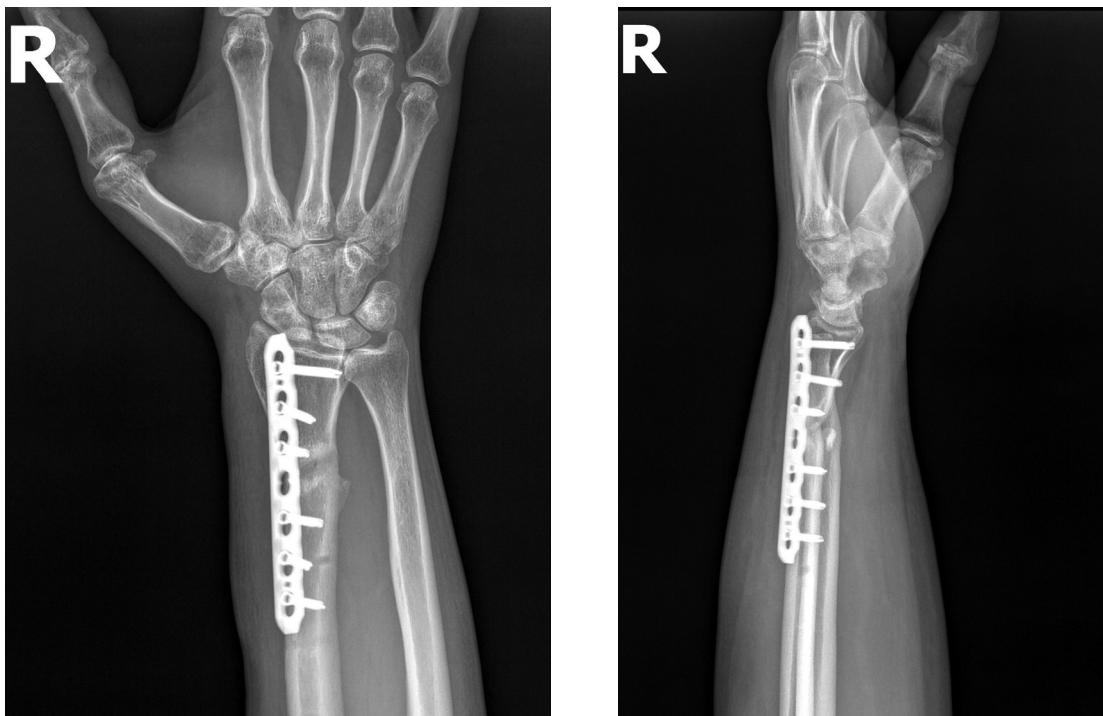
X-ray image of a fracture of the right radius in the consolidation stage (6 months after injury). There are radiological signs of callus formation
